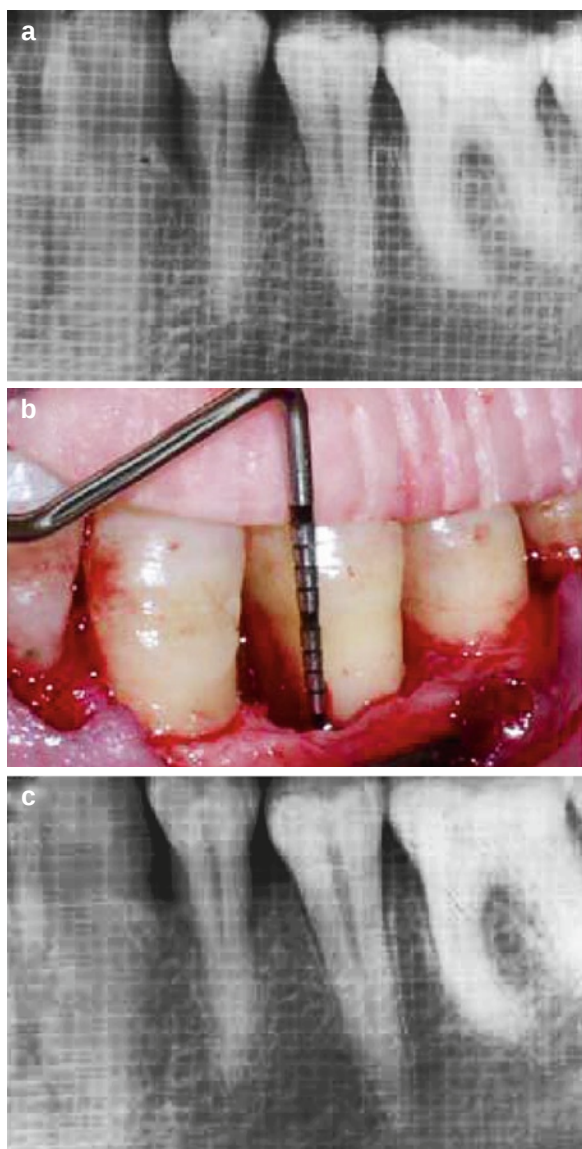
Enamel matrix derivative alone in wide intrabony defects. (a) A preoperative radiographic appearance. (b) Intrabony component of the defect. (c) At 8 months after treatment with enamel matrix derivative (Kuru et al. 2006) (Reprinted with permission from Springer)
